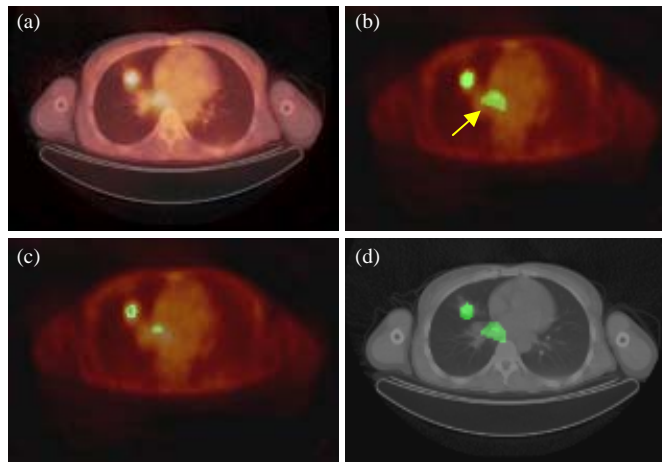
Overview of the segmentation-based spatial transfer function applied to PET/CT visualization. (a) Original PET image (single axial-view slice) with segmented structures highlighted (arrow); (b) Distance map calculated from the segmented result; (c) PET/CT fused result from spatial transfer function using (b).
